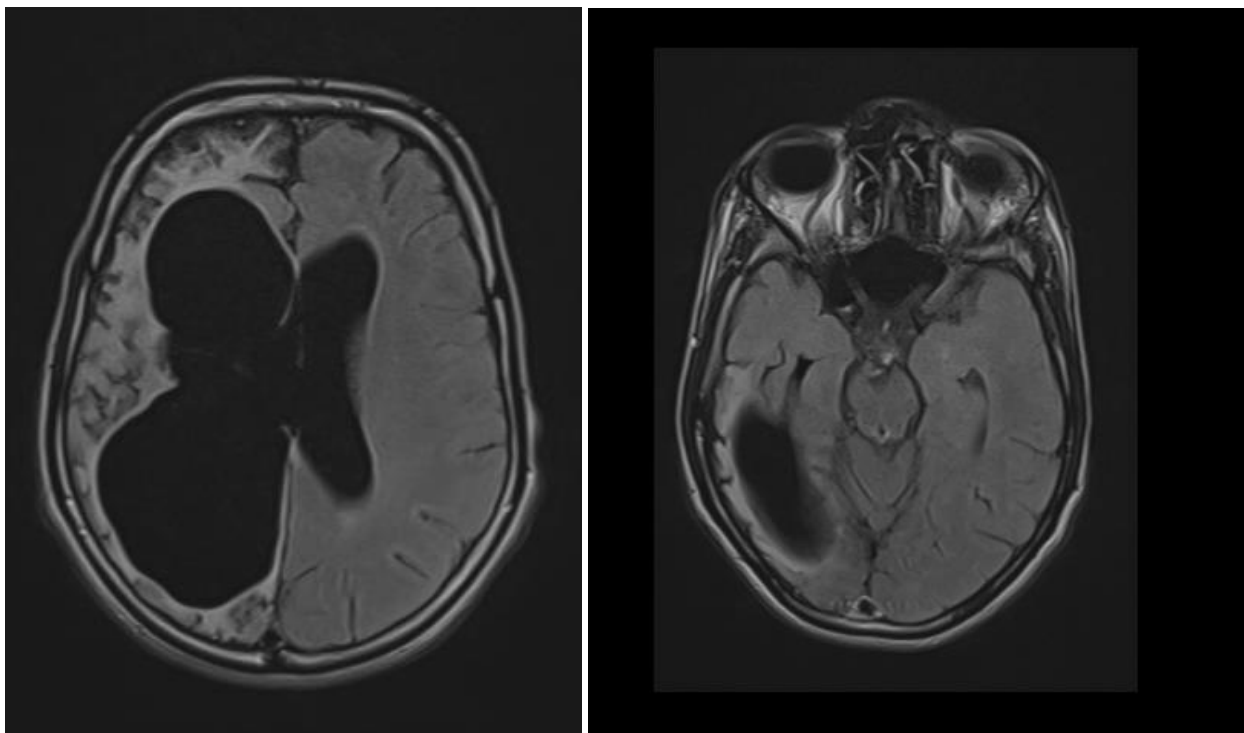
T2 and FLAIR hypersignal of the subcortical white matter is associated with gliosis. Hypotrophic appearance of right basal ganglia, corpus callosum and cerebral peduncle
